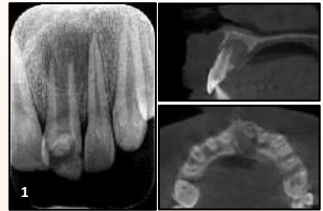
pre-op radiographs
